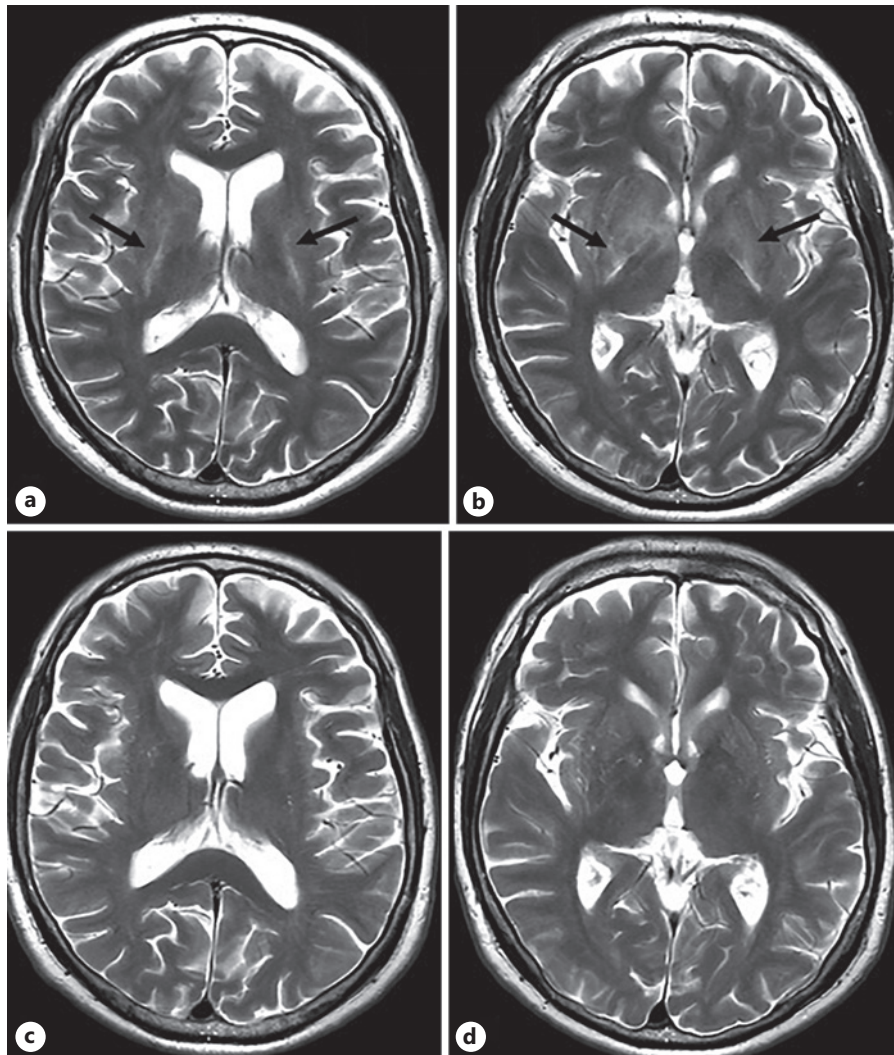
Magnetic resonance (MR) work-up: four T2-weighted axial transverse views. Upper row: views from examination dated June 13 (day 13); lower row: similar slice locations in July 7 (day 37). a Symmetrical and linear abnormally increased signal intensity along the medial border of the globi pallidi (arrows). b Slightly more caudal slice than previous view revealing symmetrical hyperintense signal changes (arrows) involving the whole lenticular nuclei (globi pallidi + putamina). c, d Electronically co-registered views allowing comparison between slices in strictly similar location (a with c and to b with d) demonstrated complete subsidence of the abnormal signal intensities 3 weeks later.
